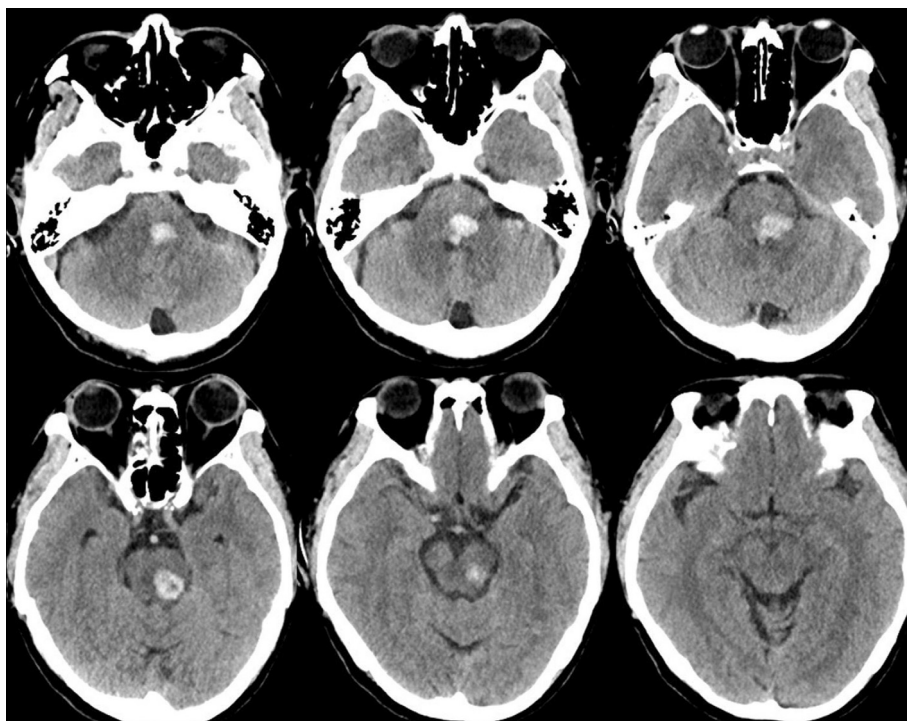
Preoperative computed tomography imaging showing acute intracerebral hemorrhage in the left midbrain and pontine tegmentum.
